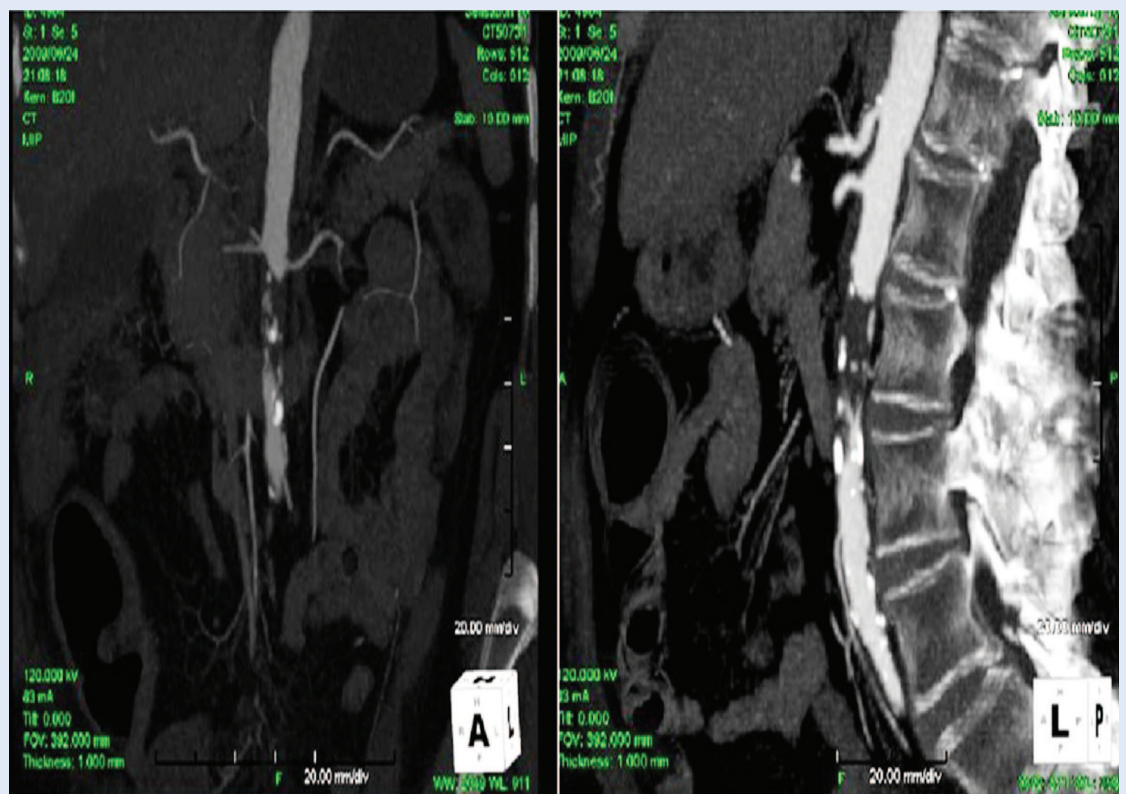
Multi-slice CT of the aorta (coronal and sagittal plane): thrombotic masses in the infrarenal part of the vessel which fulfill the lumen in the length of 4cm and fill the distal segment of the aorta right before bifurcation via collateral vessels.
